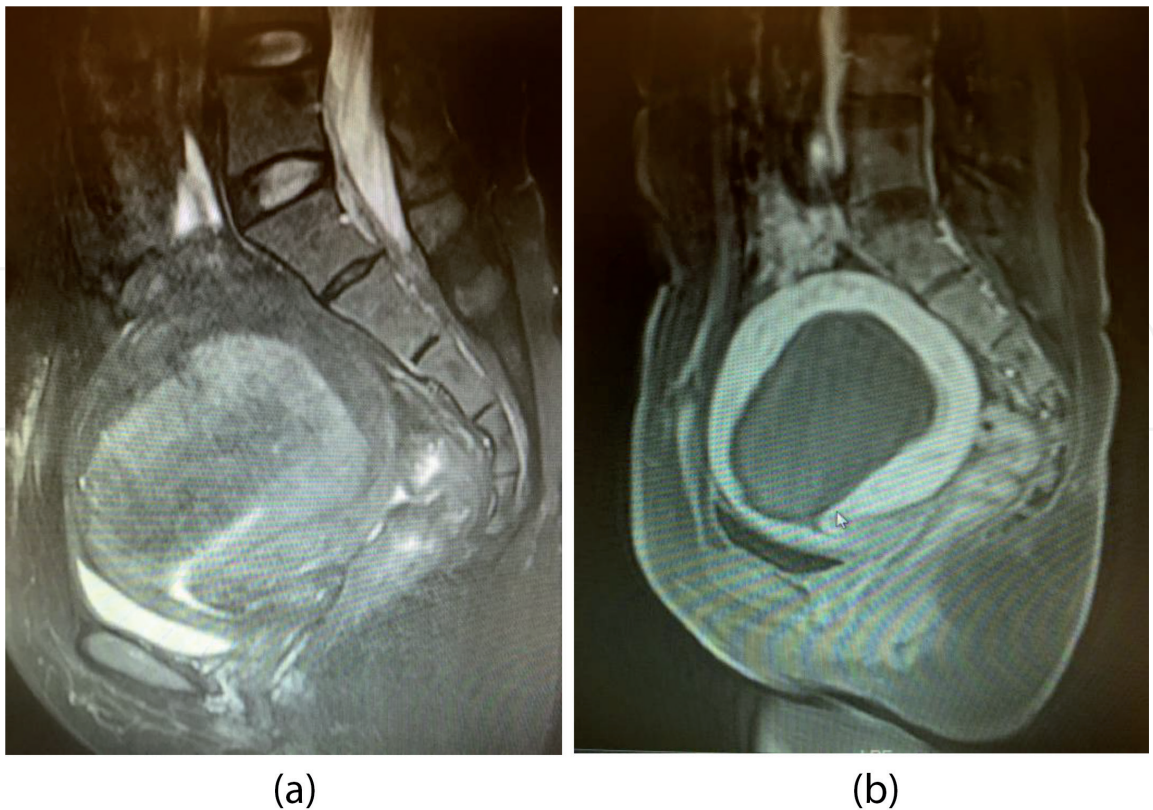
MRI of adenomyosis in (a) showed the diffuse lesion before HIFU, and (b) showed the nonperfused area of the lesion without damage to the surrounding normal tissue after HIFU.
